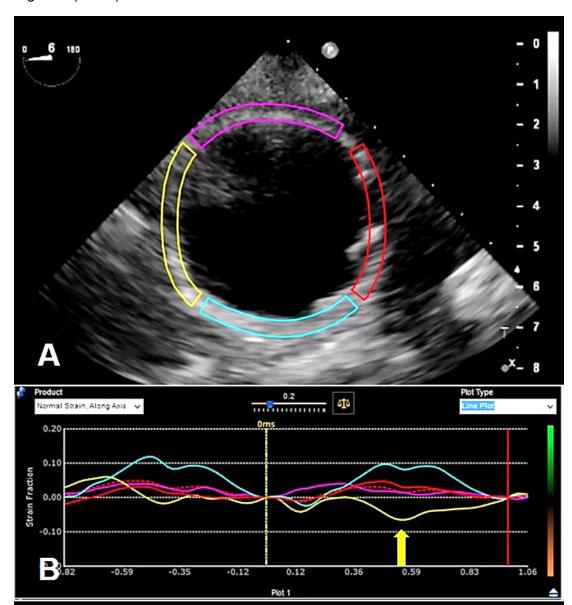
Selected example of circumferential ascending aortic strain analysis from our study using Echolnsight speckle-tracking echocardiography software (Epsilon Imaging, USA). (A) The short axis image of the ascending aortic aneurysm obtained from intra-operative TEE is divided into 4-regions: anterior (cyan), lateral (yellow), posterior (purple), and medial (red). (B) Strain analysis during systolic pulse-wave transmission shows the lateral wall with negative strain (yellow arrow) while the other walls have positive strain. Note: Color of solid plot lines in (B) correspond to regions identified on (A), while the red-hashed line demarks global strain.
